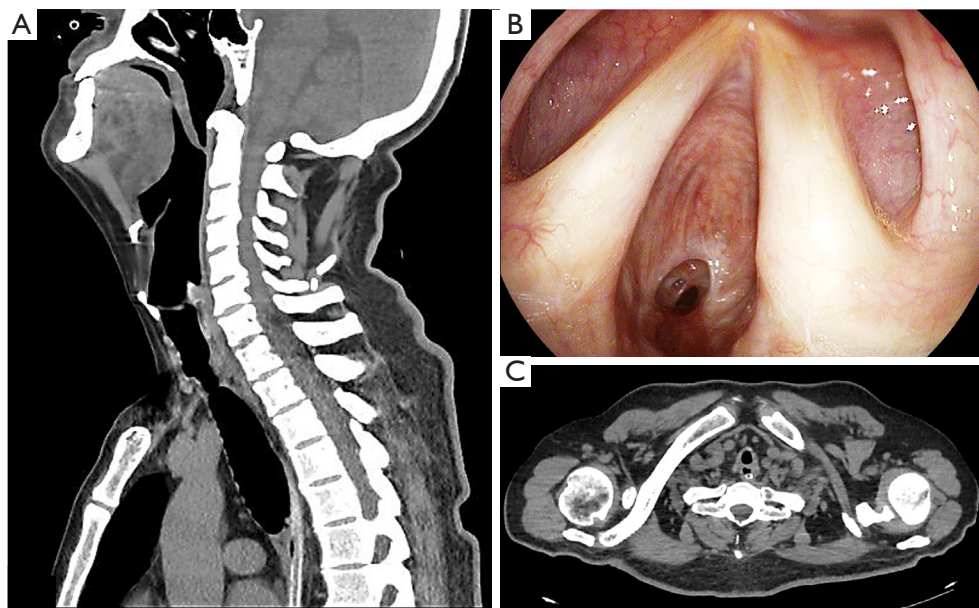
Severe subglottic and TS showed by thoracic CT-scan and fiberoptic bronchoscopy. (A) Sagittal thoracic CT-scan showing severe subglottic and TS; (B) fiberoptic bronchoscopy showing severe subglottic and TS; (C) axial thoracic CT-scan showing severe subglottic and TS. TS, tracheal stenosis.
